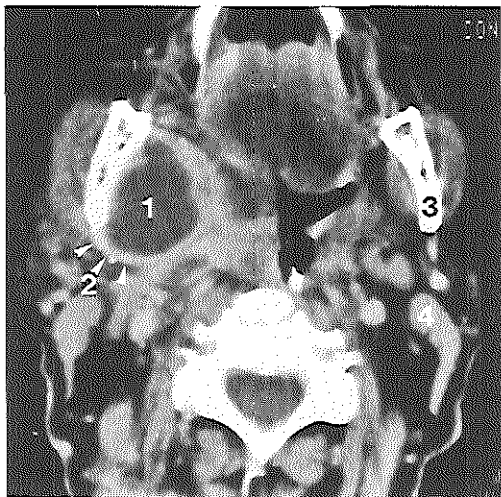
Transverse CT section of a parapharyngeal abscess before ultrasound guided catheter drainage. An encapsulated area with low density, on the basis of fluid, adjacent to the ramus of the mandible.
